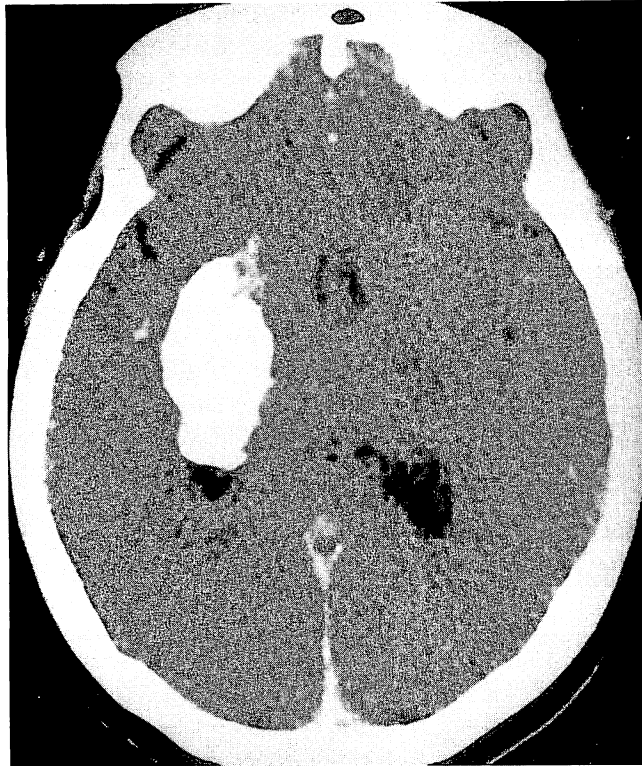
Case 1.* CT scan immediately after fibrinolysis shows high-density area (CT number = 230) at the right basal ganglia, strongly suggestive of the extravasated contrast medium.
